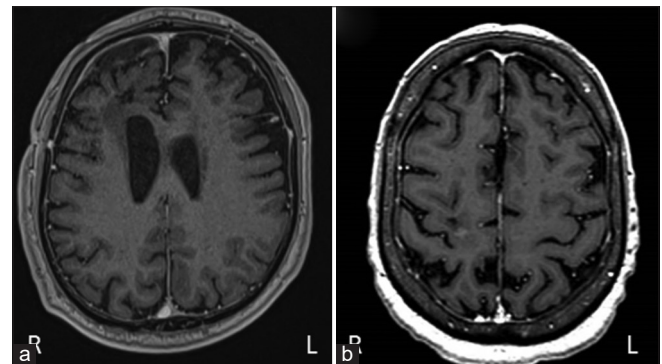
Postoperative magnetic resonance image (contrast-enhanced T1-weighted images). Total resection of the tumor was achieved in the patient 1 (a). The patient 2 present millimetric remains in the surgical site (b).
